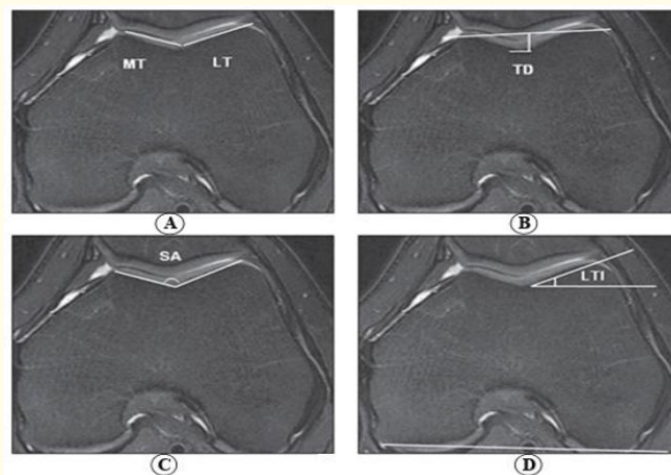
MR Images show axial measurements in 16 years girl who underwent knee MRI. A: Trochlear facet asymmetry. AT= Lateral Trochlea. B: Trochlear depth (TD). C: Sulcus angle (SA). D: Lateral trochlear inclination (LTI).
